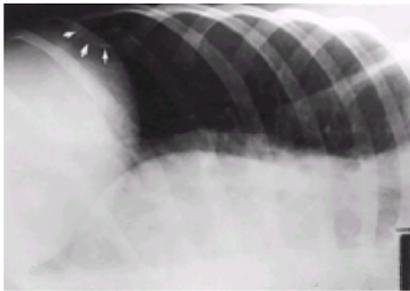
Standard x-ray film of the rib showing fibrous dysplasia (arrows). The cortex is expanded, and a lytic core is prominent.
